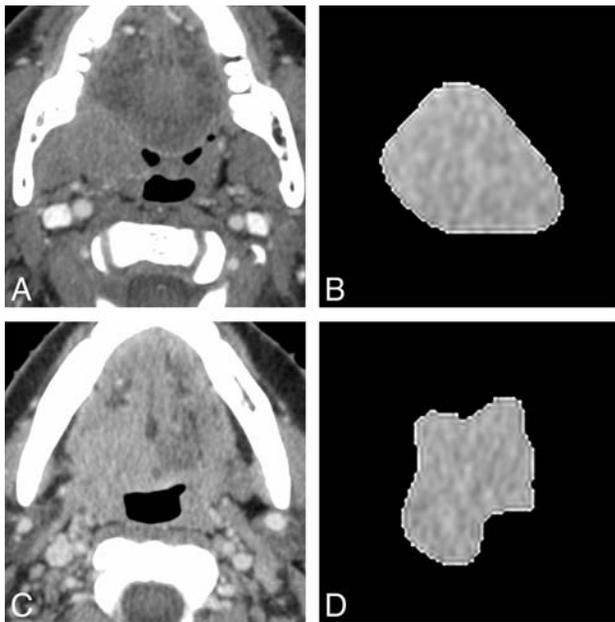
Representative axial contrast-enhanced CT images (A and C) and corresponding axial section ROI mask-segmented primary tumor (B and D) for 2 different patients with oropharyngeal squamous cell carcinoma. Segmented tumor is from a 75-year-old man (B) with right tonsil squamous cell carcinoma (HPV-positive; smoking, 0 pack-year; tumor volume, 16.4 mL; clinical T-stage, T4) who developed local failure and a 43-year-old woman (D) with squamous cell carcinoma of the right base of tongue (HPV-positive; smoking, 0 pack-year; tumor volume, 20.6 mL; clinical T-stage, T4) who showed local control. Representative texture features of each patients are as follows; for geometric mean, 973.2 (local failure, B) and 906.6 (local control, D); for harmonic mean, 285.1 (local failure, B) and 210.3 (local control, D); for SRE, 0.026 (local failure, B) and 0.043 (local control, D); for GLN, 0.026 (local failure, B) and 0.042 (local control, D); for RLN, 0.019 (local failure, B) and 0.032 (local control, D); and for SRLGE, 479.1 (local failure, B) and 459.1 (local control, D).
